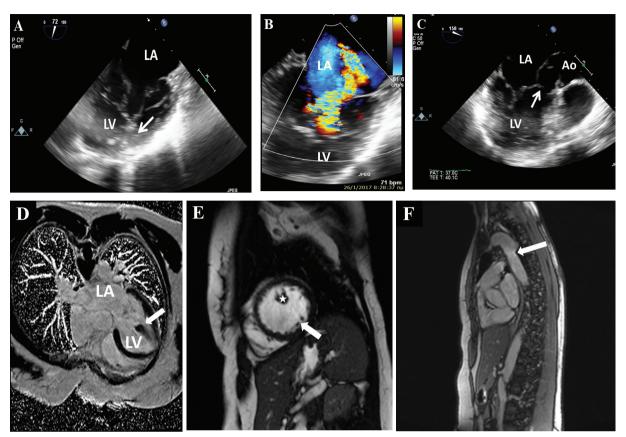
Transoesophageal echocardiogram (TOE) and cardiac magnetic resonance (CMR) images of the patient with incomplete Shone's complex. A) TOE mid-esophageal 72° view displaying the mitral valve leaflets and the tendineae chordae inserted to a single papillary muscle (arrow). B) TOE mid-esophageal 74° color-Doppler view showing the mitral valve regurgitation pattern. C) TOE mid-esophageal 158° view showing the subaortic membrane (arrow). D) CMR view displaying the chordae tendineae attached to the dominant anterolateral papillary muscle (arrow). E) CMR short axis view displaying the left ventricle with the hypertrophic anterolateral papillary muscle (asterisk) and the hypoplastic posteromedial papillary muscle (arrow) F) CMR view of the aorta displaying the mild stenosis at the isthmus level (arrow). Ao: aorta, LA: left atrium, LV: left ventricle.
